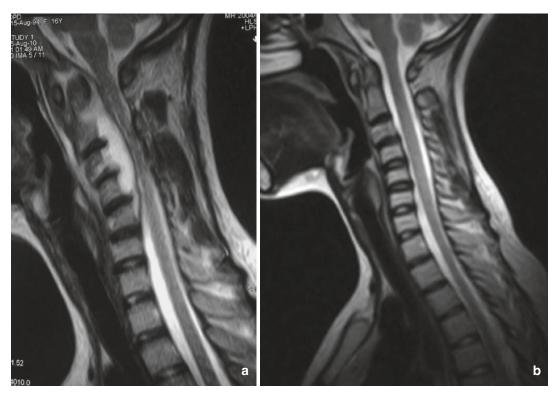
A 16-year-old female patient treated conservatively with medical treatment only: (a) sagittal T2-WI MRI at first visit showing epidural abscess collection extending from C3 to C5 cervical vertebrae compressing
